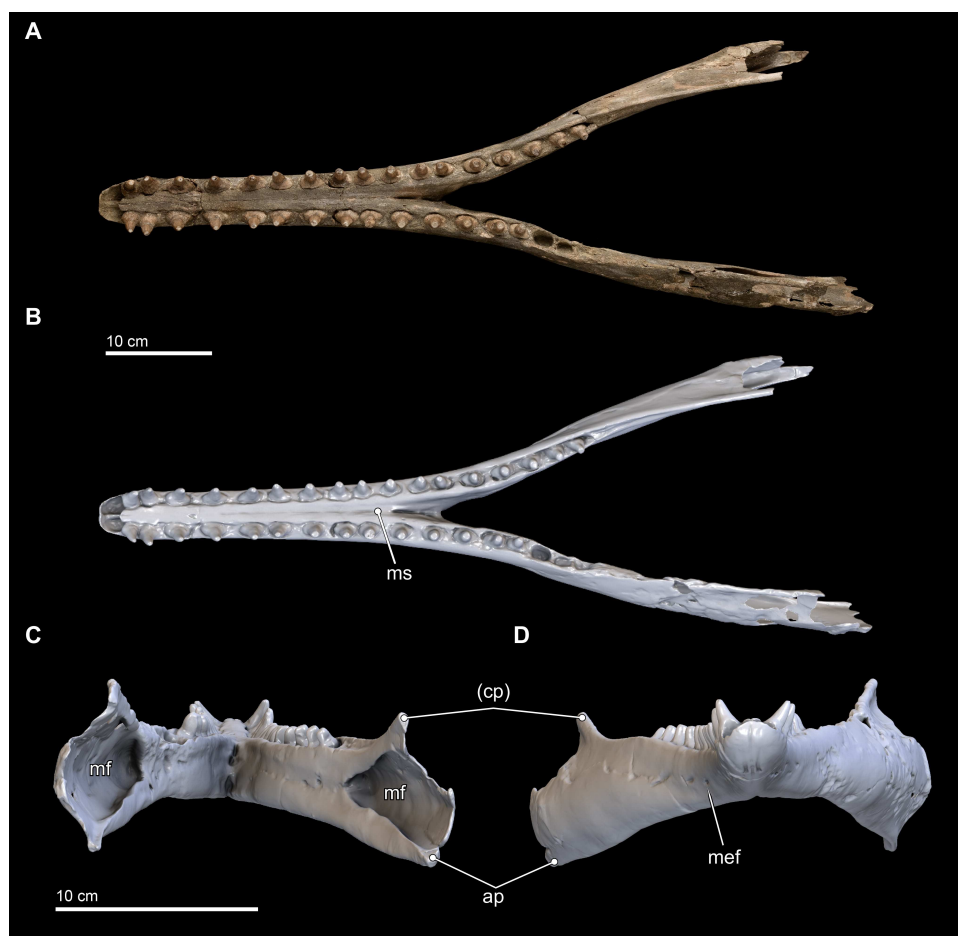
Mandibles in dorsal, anterior, and posterior views. Dorsal views of the mandibles of *Isthminia panamensis* (USNM 546125) from (A) photographs and (B) orthogonal digital three-dimensional polygon model prepared from CT data, with lighting and color modifications using the Smithsonian X 3D browser. (C) Anterior and (D) posterior views of the mandibles of *Isthminia panamensis* (USNM 546125) from orthogonal digital three-dimensional polygon model prepared from CT data. See <http://3d.si.edu/explorer?s=hhl3iu> (dorsal view), <http://3d.si.edu/explorer?s=cgvhM3> (posterior view), and <http://3d.si.edu/explorer?s=gR4Rhv> (anterior view) to measure, modify, or download this model. Parentheses denote missing structure(s).
